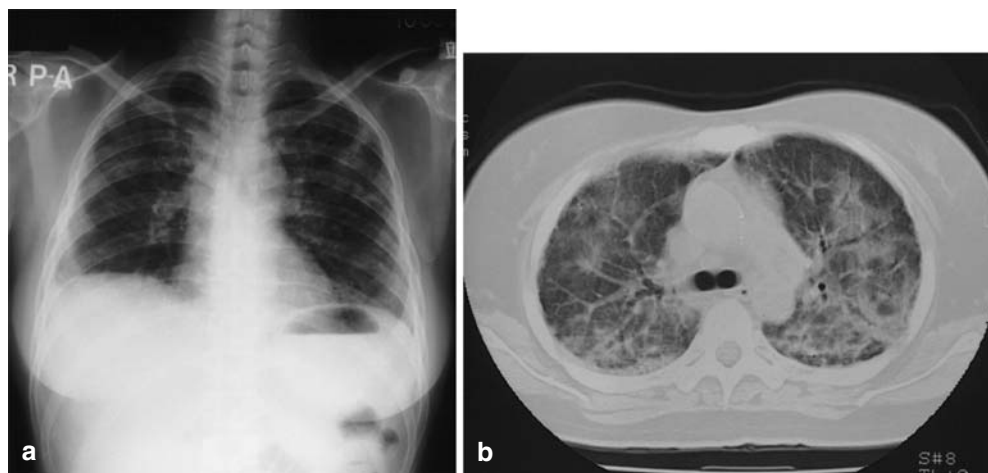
Findings of chest X-ray (a) and CT on 16 June (b)
